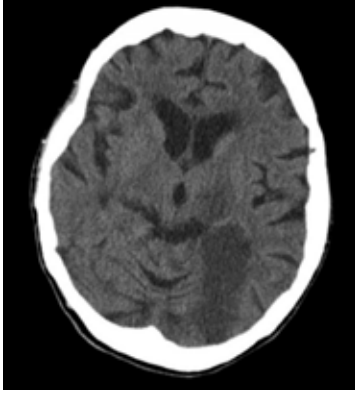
Computed tomography scan of the brain revealed a large left-sided hypo-dense.
